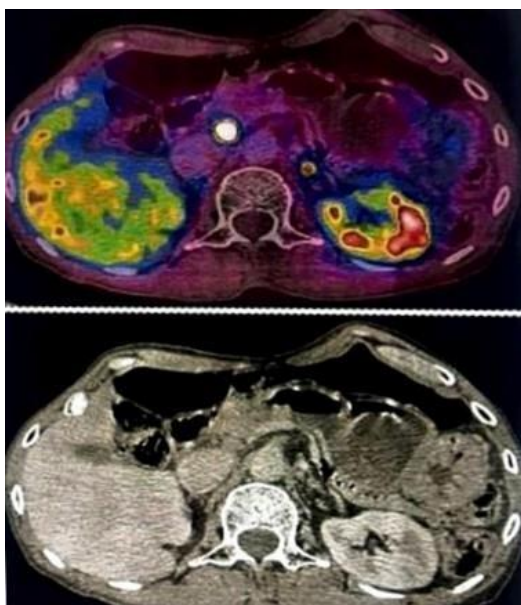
Somatostatin Receptor - Positron emission tomography computed tomography (SSTR PET-CT)
